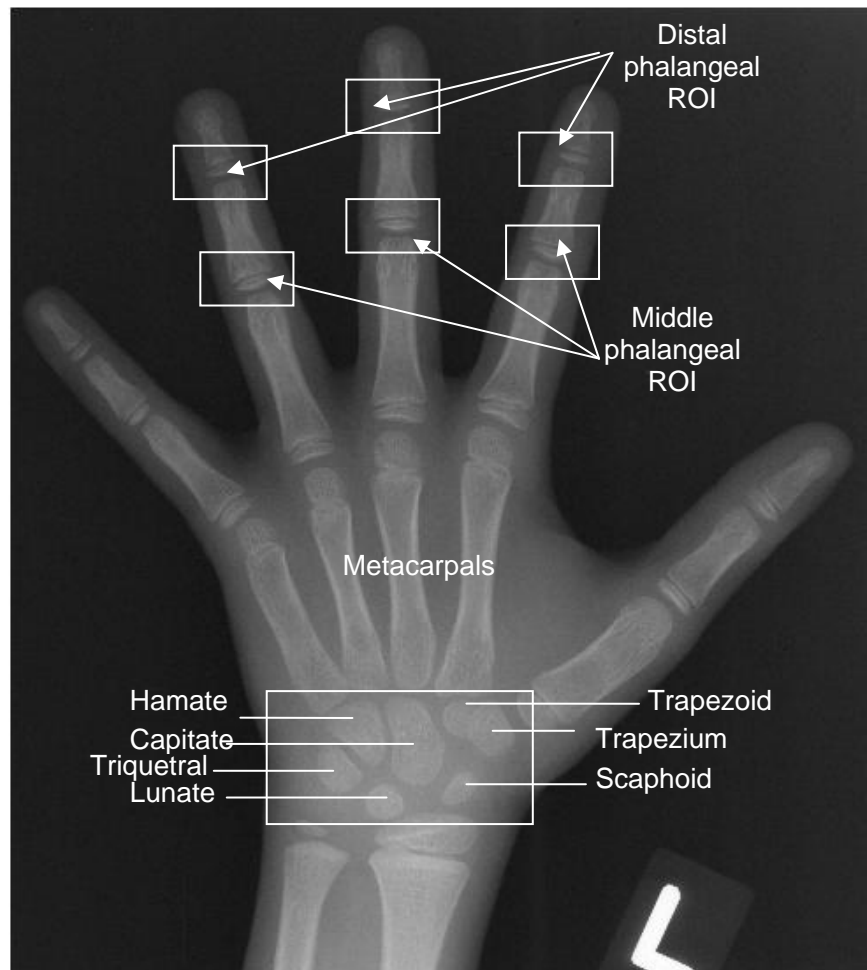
A left hand and wrist radiograph marked with 6 phalangeal ROIs and carpal ROI (box at the bottom)
